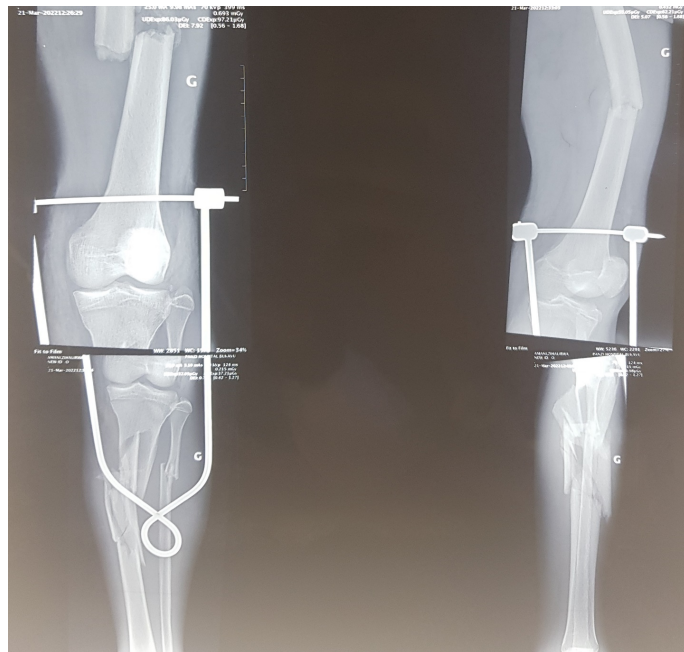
X-ray of lower left limb after double pull, frontal incidence.
